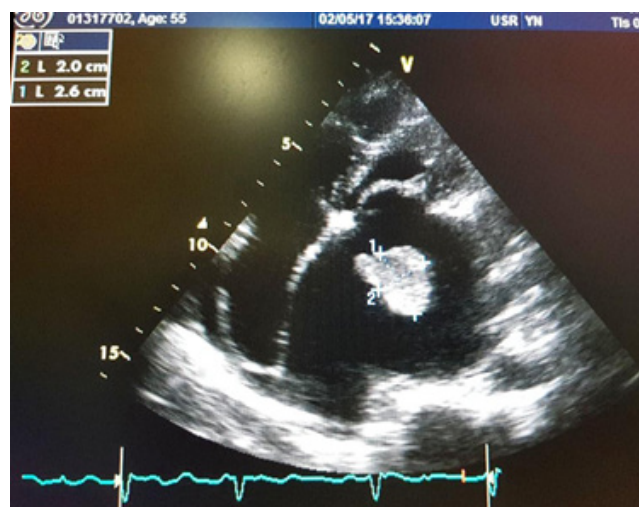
The apical four chamber view showed LA thrombus “flying” in the center of the left atrium
